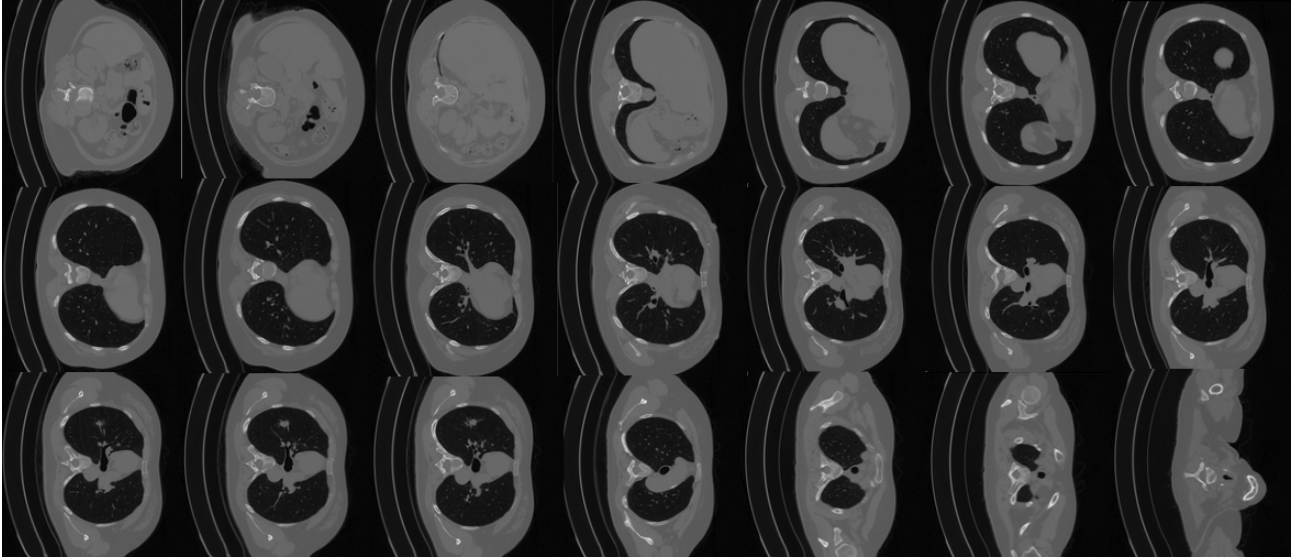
CT volume from abdomen to upper body - Train Patient 32
